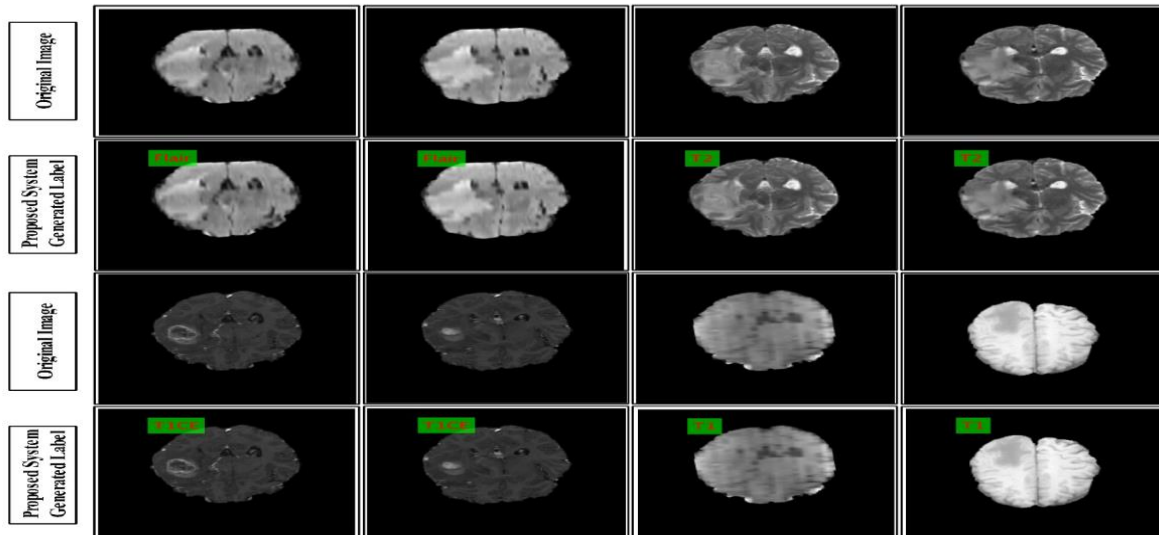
Automated labeling of multimodal brain MRI sequences using the proposed classification system.
